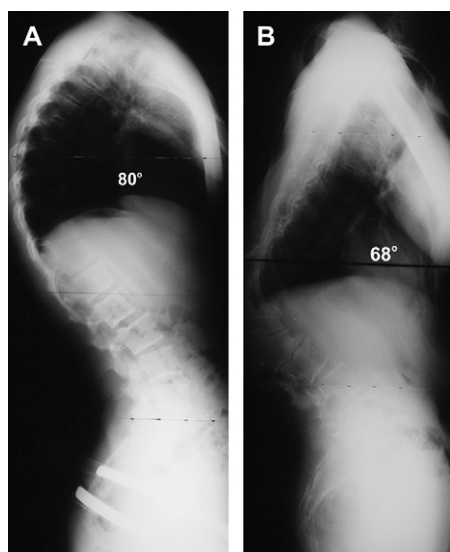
(A, B) Radiographs of the two patterns of kyphosis secondary to Scheuermann's disease.
